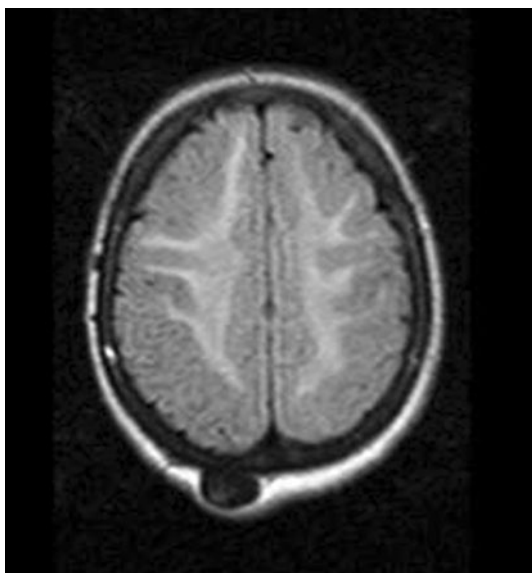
Cranial MRI with white-matter lesion on T2-weighted image (section1)
